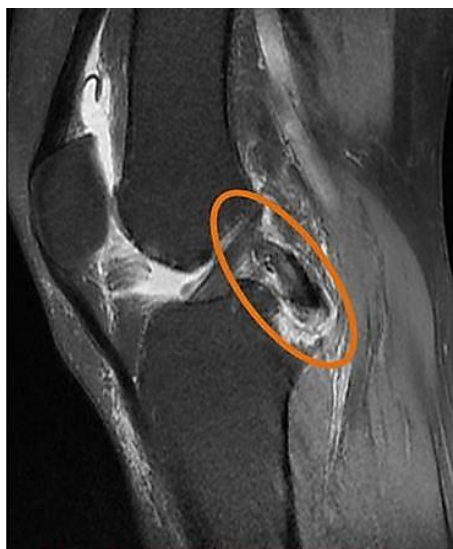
Magnetic resonance imaging (MRI) showing posterior cruciate ligament (PCL) tibial bony avulsion fracture with intact PCL (orange circle)
